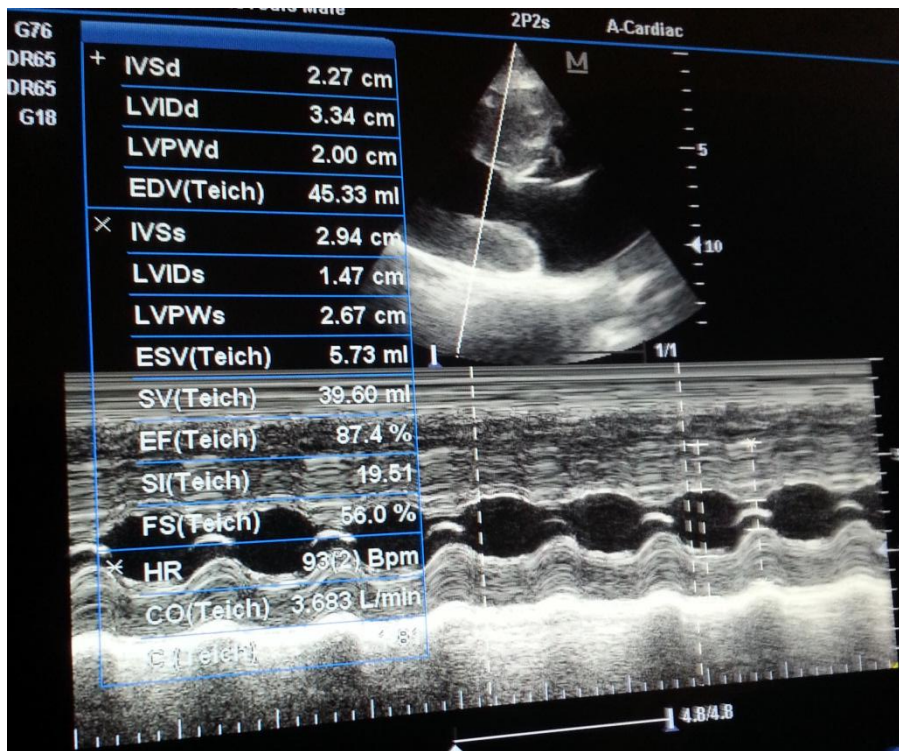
2D guided M mode echocardiogram of Case 2 revealed thickened left ventricular walls.
